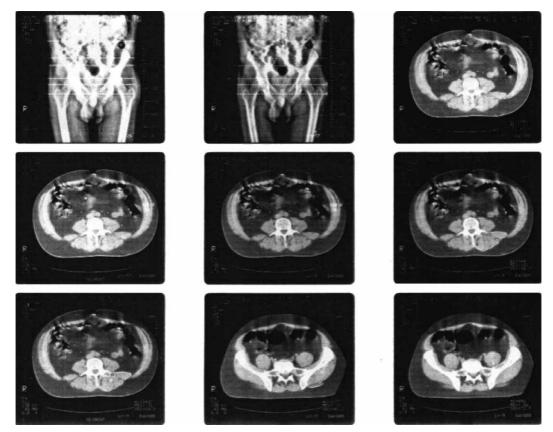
Tomogram with marked levels of transverse pelvic cross-sections. Using CT, the cross-section of abdominal and gluteal muscles and of the iliopsoas muscle was determined as well as the distance between the muscle centroid and the bone.
